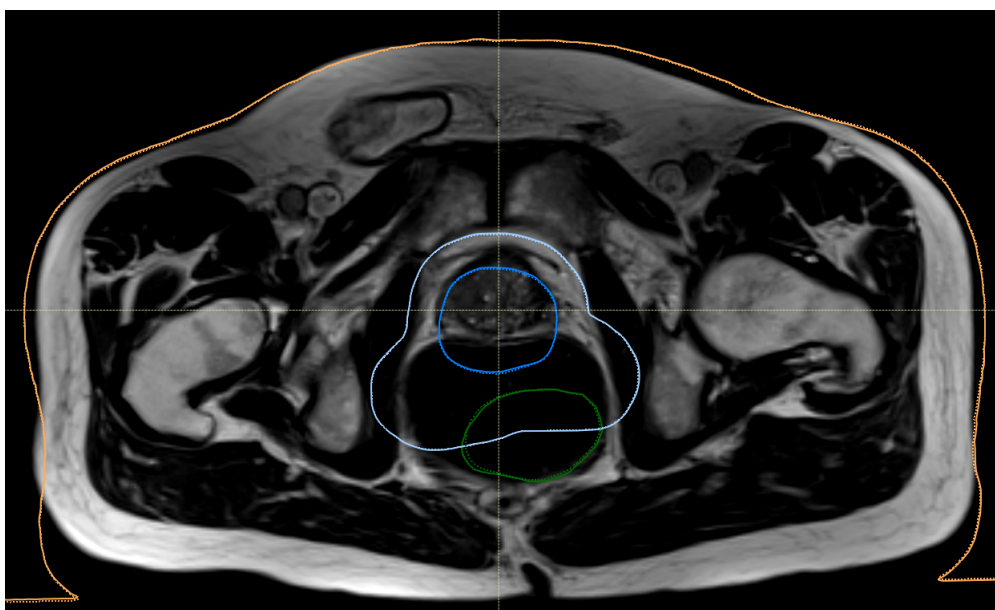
Example of MR scan from an excluded patient. Here the green structure delineates the rectum size and location in the CT scan, the orange shows the external contour from the CT, while the two blue shades show two target volumes, also mapped from the CT. Because of the large shift in rectum size and location, the CT based treatment volumes were not found to be of adequate accuracy for the MR, and so the patient was excluded.
